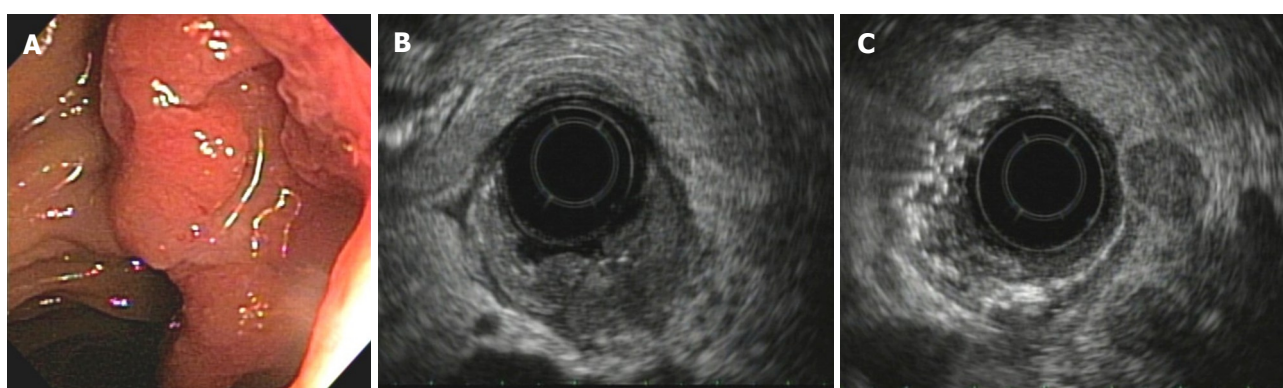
Ampullary carcinoma. A: Ulcerated ampullary tumor revealed by endoscopy; B: Duodenal wall disruption and pancreatic invasion in radial endoscopic ultrasound of the same tumor; C: Tumoral lymph nodes (same patient). Palliative therapy was indicated.
